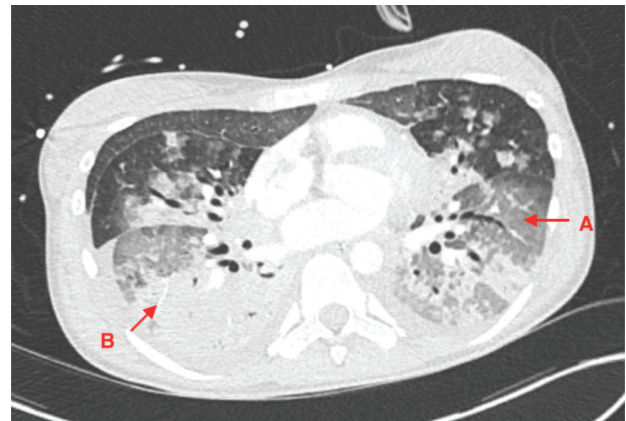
Initial CT scan revealing bilateral anterior GGO (A) and posterior consolidations (B). GGO: ground-glass opacities.
